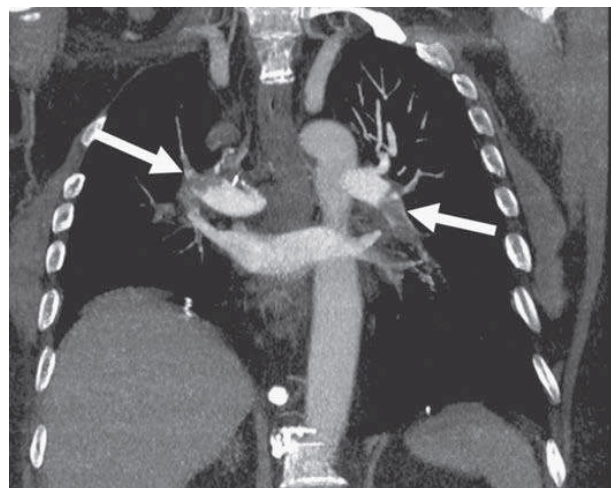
Large bilateral proximal PE on a coronal chest CT image. There are filling defects in the primary and segmental pulmonary arteries bilaterally (white arrows). Only the left upper lobe segmental artery is free of thrombus.
